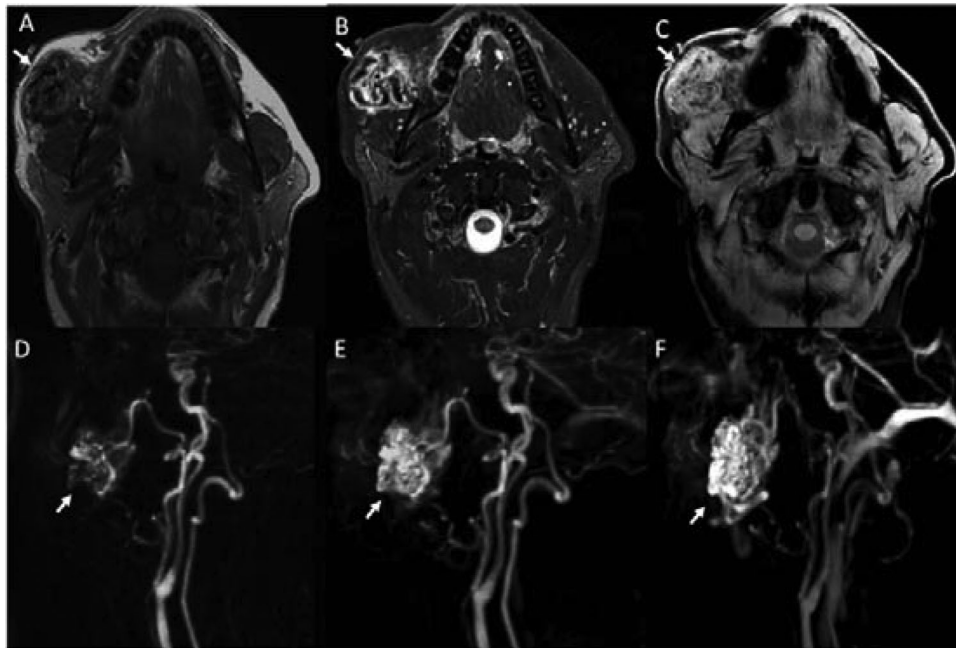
Axial T1-weighted (A), fat-suppressed T2-weighted (B), and contrast enhanced fat-suppressed T1-weighted (C) MR images of a child with an arteriovenous malformation. The T2-weighted images (B) show dark, serpiginous flow voids infiltrating the subcutaneous fat of the right cheek. The contrast-enhanced image (C) reveals an additional soft tissue infiltrating component of the lesion. Multiphase dynamic contrast-enhanced MRA images (D-F) reveal early arterial enhancement of the lesion with feeders identified from the external carotid artery. Note the intralesional nidus formed by the tangle of vessels (E, F).
